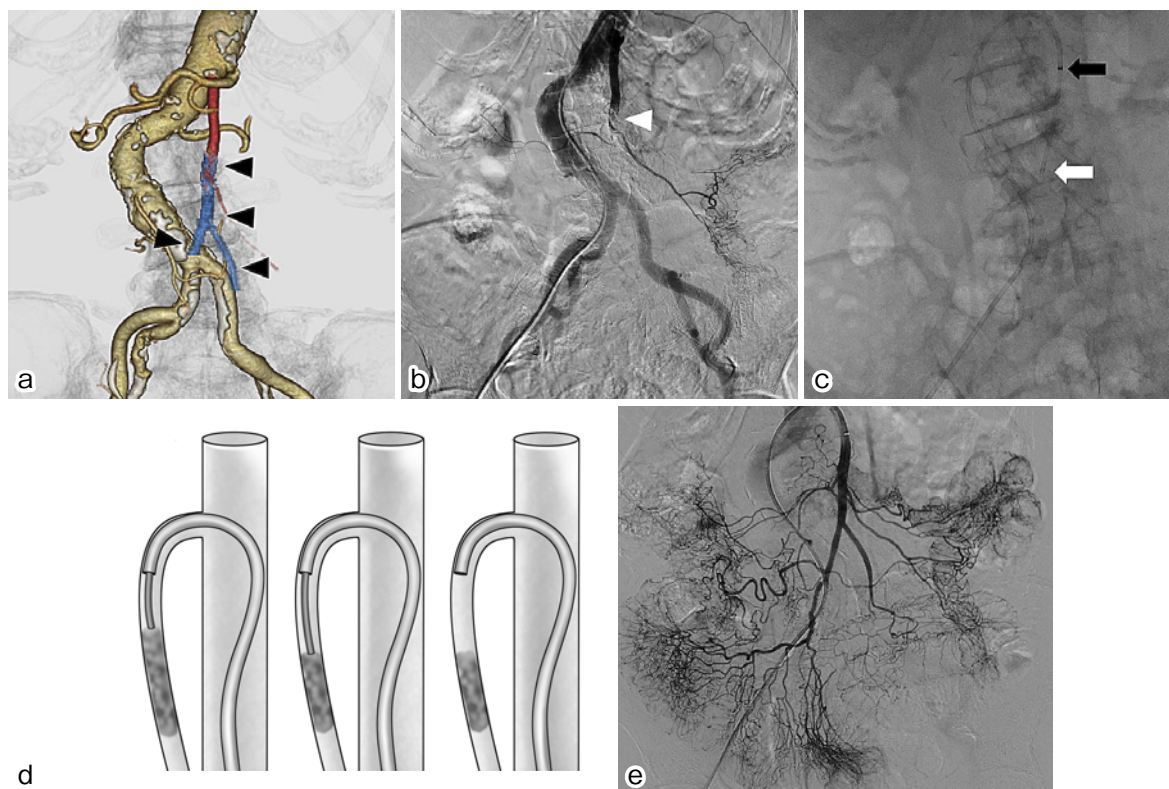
A woman in her 90s with a history of atrial fibrillation presented at the hospital with sudden abdominal pain. a: Contrast-enhanced computed tomography (CECT) revealed occlusion of the main trunk of the SMA (indicated by black arrowheads). b: Selective angiography of the SMA demonstrated the findings similar to those observed in the preoperative CECT (indicated by white arrowhead). c: Image captured during thrombus aspiration of the SMA shows the tips of the 6Fr guiding catheter (Mach-1™, Boston Scientific, Natick, Massachusetts, USA, indicated by the white arrow) and sheath (Flexor Ansel™ Guiding Sheath, Cook Medical, Bloomington, IN, USA, indicated by the black arrow). d: Aspirating the thrombus using large bore guiding catheters to bite off the thrombus from proximally can aspirate the thrombus with minimal complications of distal embolization. e: Angiography after thrombus aspiration confirmed the re-establishment of blood flow in the SMA.
